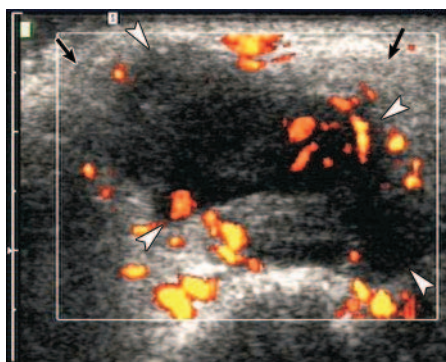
Power Doppler US image shows a metastasis (arrowheads) to the superficial lobe of the parotid gland (arrows) from a melanoma. The tumor is lobulated, inhomogeneous, and virtually anechoic with posterior acoustic enhancement and chaotic, mainly peripheral vessel segments.
